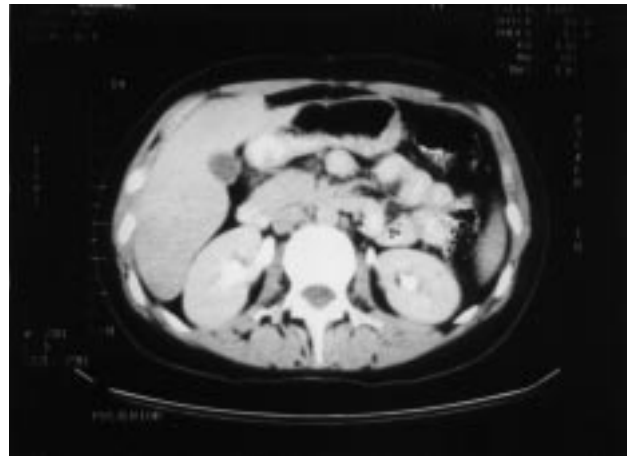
Microphotograph of computed tomography scan. Thickening in the wall of lesser curvature because of the infiltrating gastric adenocarcinoma is seen.
